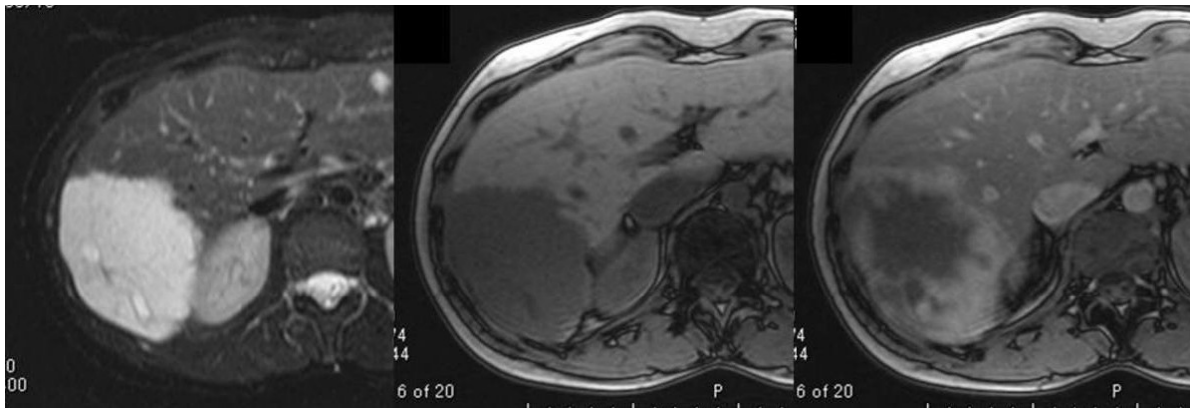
MRI demonstrating haemangioma liver.
